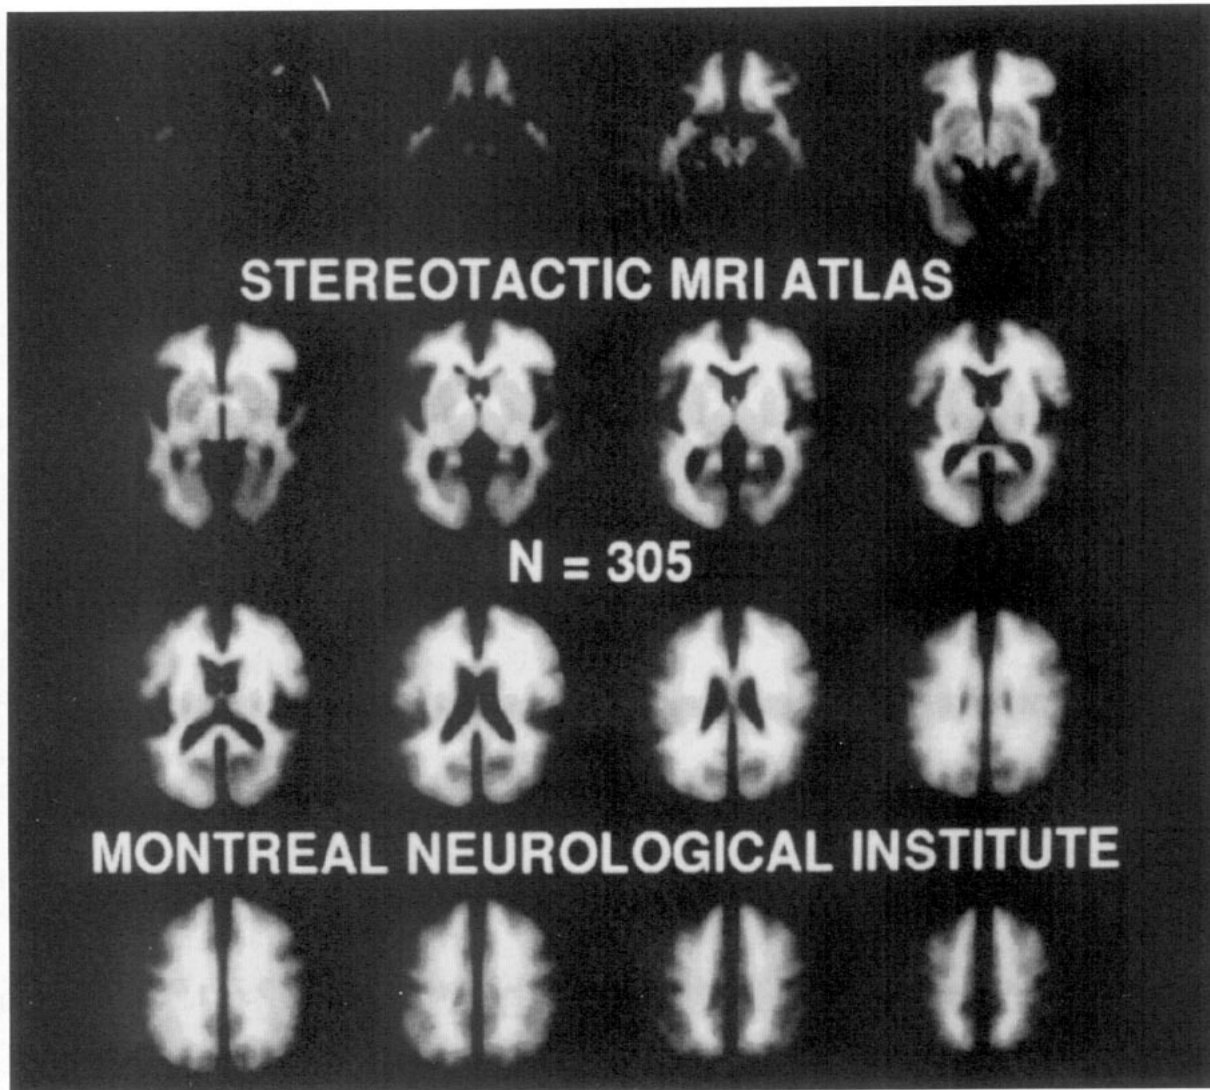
Stereotaxic MRI atlas. Three hundred five MRI volumes (2-mm thick slices) were mapped by linear transformation into stereotaxic space, intensity normalized, and averaged (Evans *et al.*, 1992).
